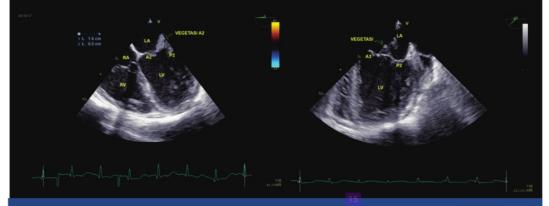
Transesophageal echocardiography showed there was vegetation in the anterior mitral valve leaflets (A2) and posterior mitral valve leaflets (P3).
